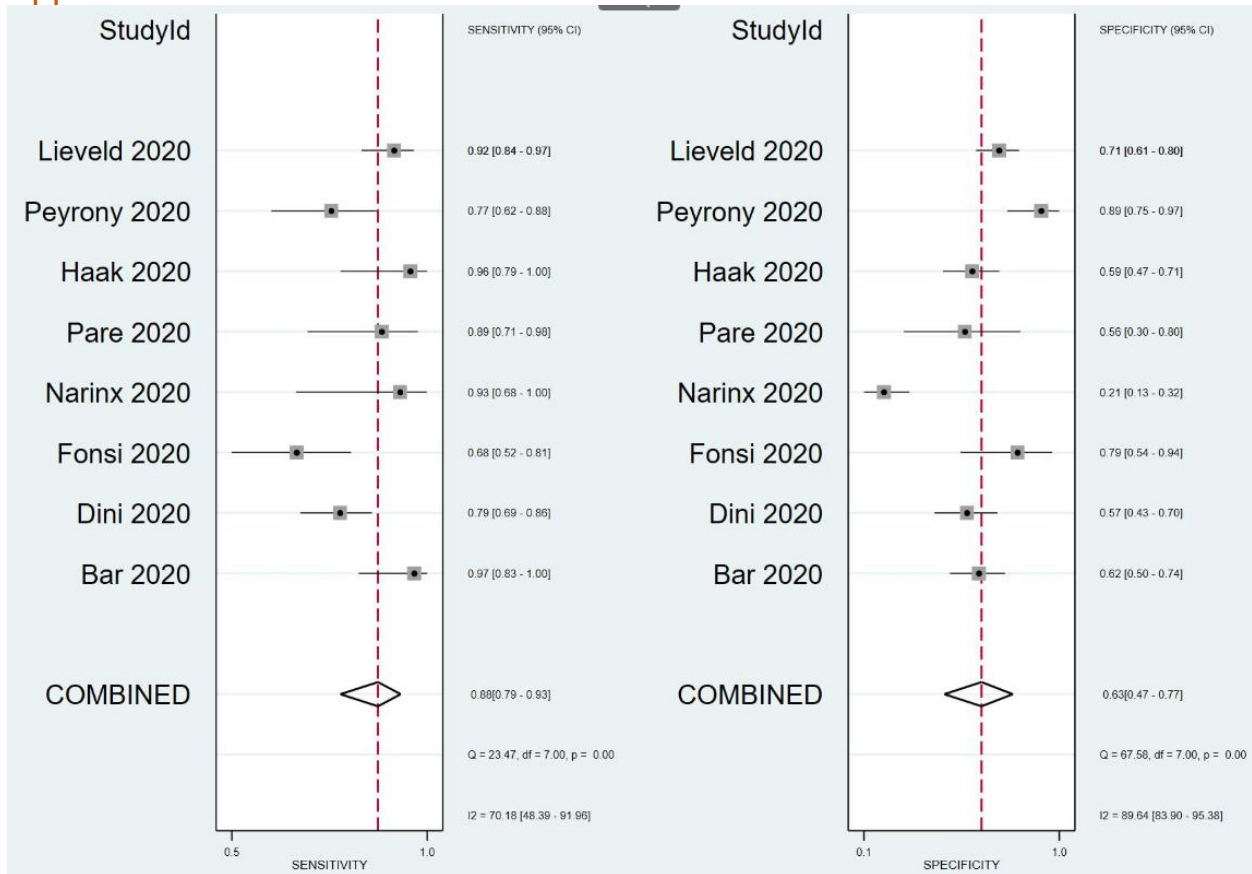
Forest plot of diagnostic performance of lung ultrasound compared with RT-PCR (n =8 studies)
